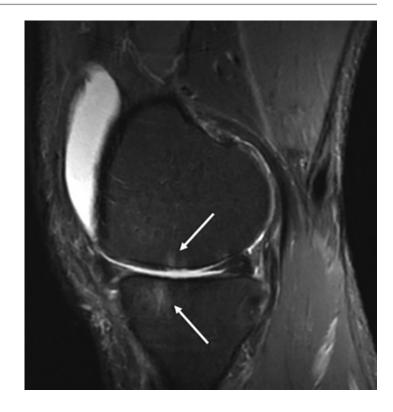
MRI using fat-suppressed T2-weighted fast spin-echo (STIR) sequence demonstrating the presence of bone marrow lesions in the distal femur and proximal tibia in a patient with OA (Courtesy of Hollis Potter, MD, Hospital for Special Surgery, New York, NY)
